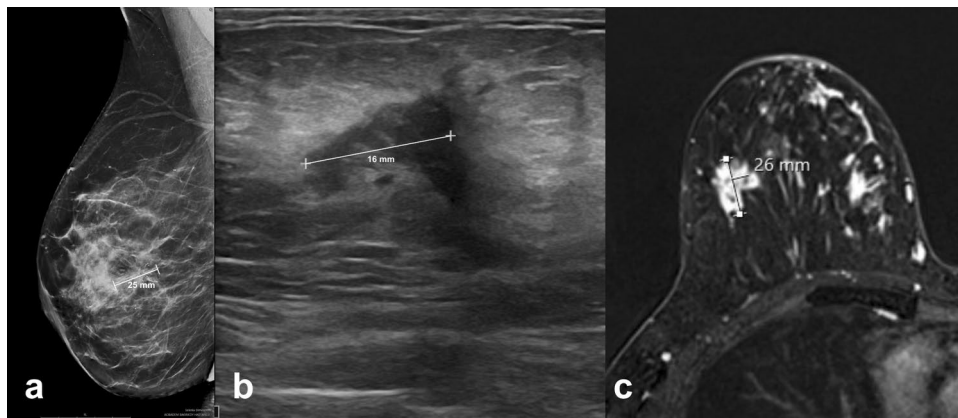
A 39-year-old woman with a palpable tumor in the upper outer quadrant of her right breast showed pathological microcalcifications and accompanying distortion in an area of approximately 25 mm on MMG (a). The widest lesion size measured 16 mm on US (b) and 26 mm on axial contrast-enhanced fat-suppressed T1-weighted MRI
